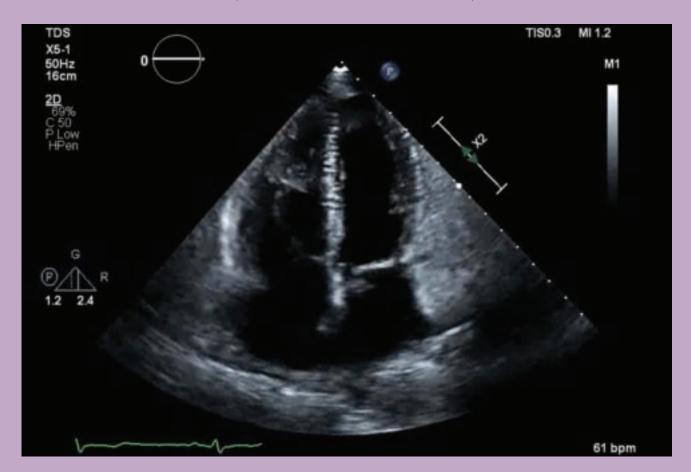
Echocardiogram that reveals a dilated right atrium and ventricle with intraventricular septal flattening in a patient with scleroderma-associated PH.
